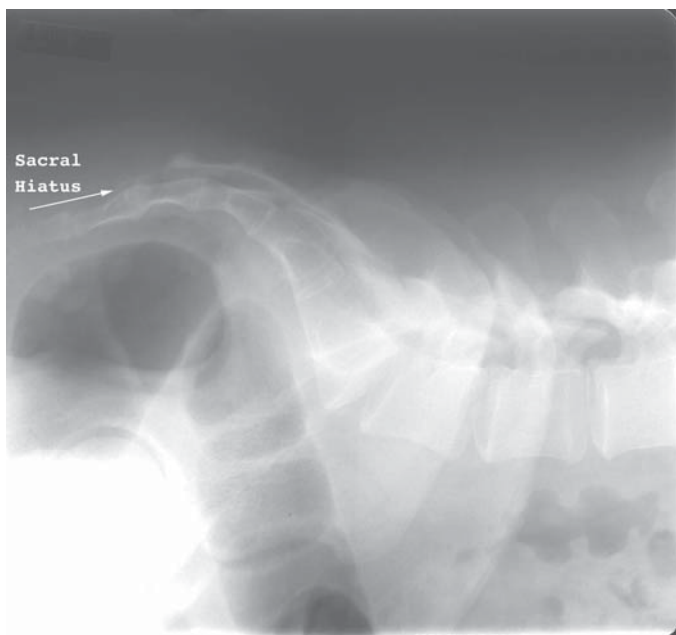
Lateral radiograph of the sacrum shows the sacral hiatus, which is the access for the caudal technique.
